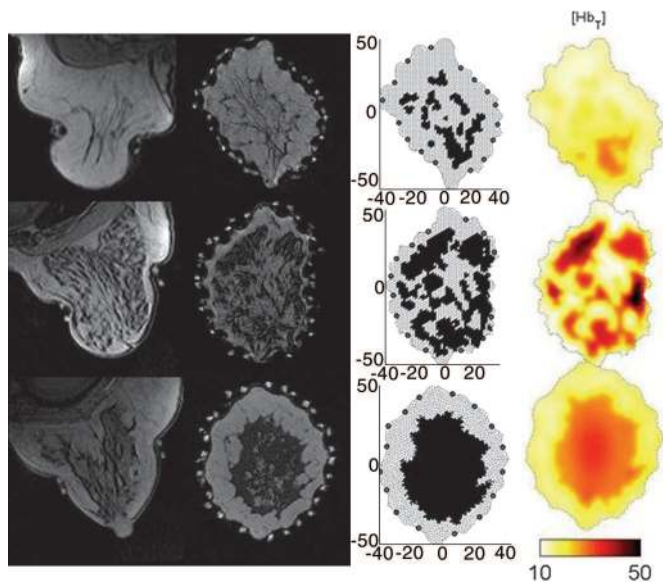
Breast images are displayed from MRI and NIR. Anatomically axial (column 1 from left) and coronal (column 2) T1-weighted MR scans through three normal breasts. The coronal slices correspond to the plane of NIR measurement. Fiducial markers attached to each optical fiber are visible at the tissue perimeter and are projected onto the model surface (as dots in column 3). Coronal slices are used to create 2D meshes (column 3), which accurately represent the breast structure in the plane of interest, as well as to locate the measurement positions with millimeter accuracy. Each mesh location (node) is classified to define either adipose or fibroglandular tissue based on segmentation of the MRI grayscale intensities, and the dimensions are shown in millimeters, in the middle column of breast meshes. These meshes are used in the NIR image reconstruction from simultaneously acquired optical data. Images of the corresponding total hemoglobin concentration ($[Hb_T]$, μM) are shown in column 4.
